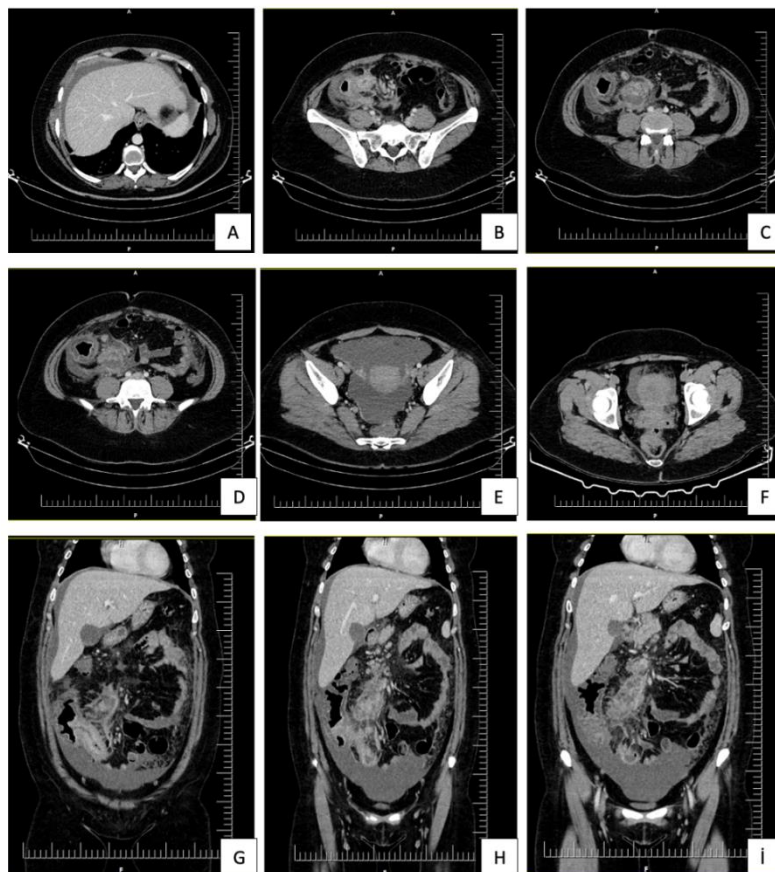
Abdominal computed tomography images (A. Perihepatic free fluid, B. Wall thickening in the cecum and surrounding fat stranding, C. Extensive lymph nodes in the ileocecal mesentery, D. Necrotic conglomerate lymph node, E, F. Widespread pelvic fluid, G-I. Lymphadenopathy near the portal hilum, paraaortic region, superior mesenteric artery, and celiac trunk; free fluid in the right paracolic gutter, perihepatic, and pelvic areas)
